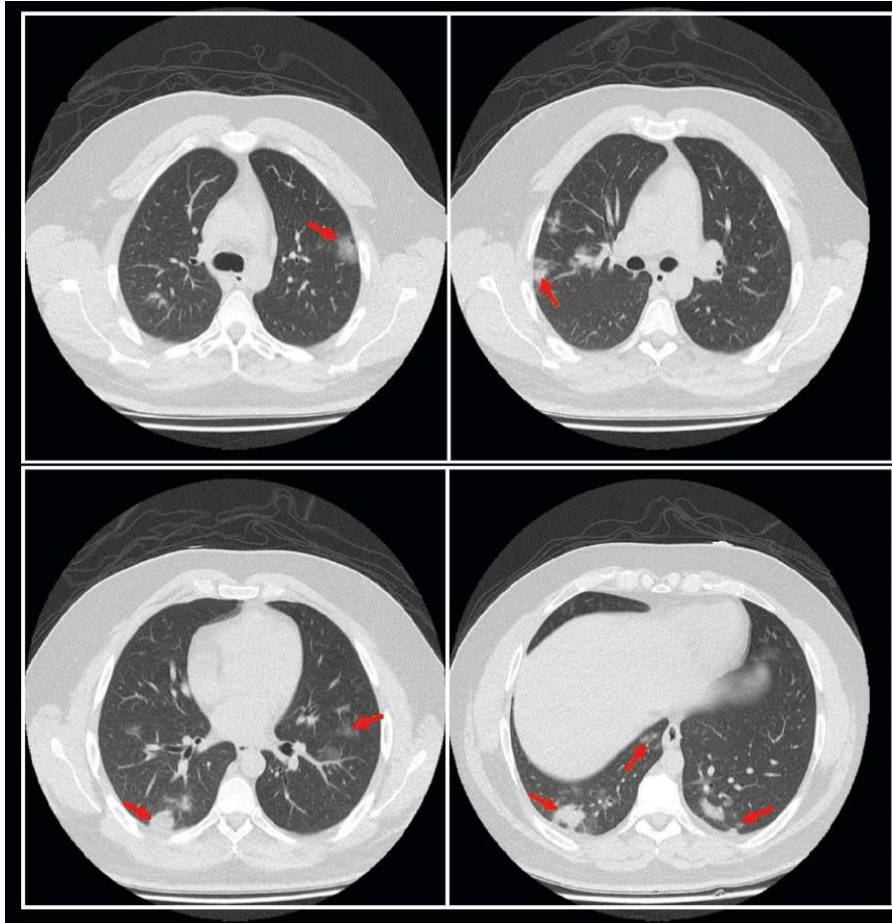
HRCT image indicating the presence of CORONA virus in lungs
